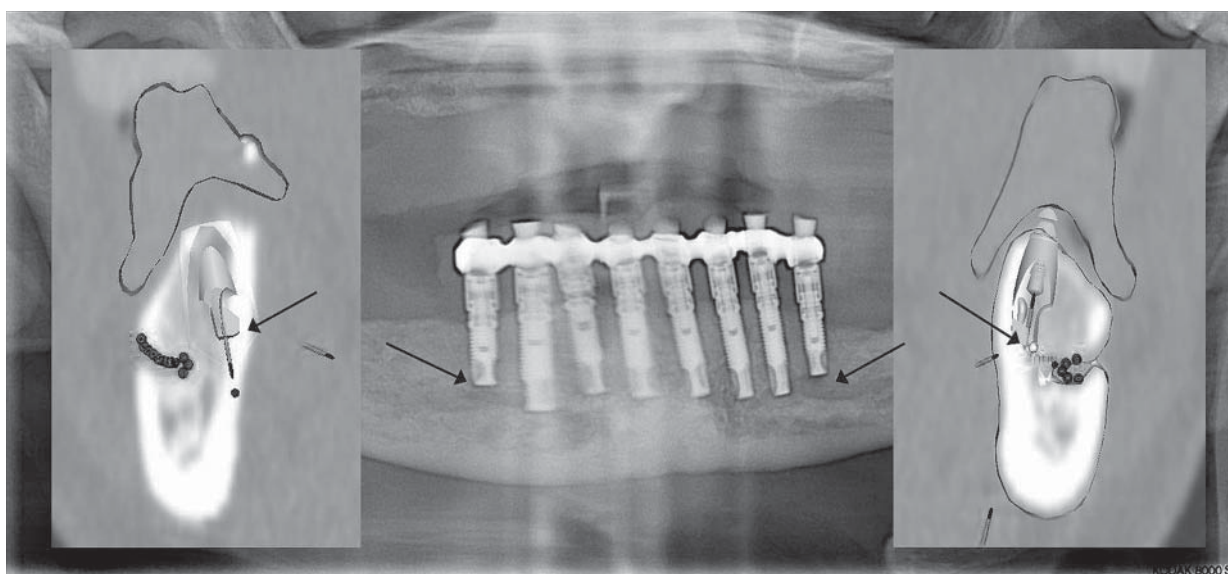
Postoperative panoramic radiograph of an 8 implant mandibular case (center image.) Note that in this image the most posterior implants appear to be encroaching on the mental foramina bilaterally. Compare this with the images on the right and left showing the planned positioning of the implants in the virtual treatment plan. Surgically, the implants were placed lingual to the mental foramina.
